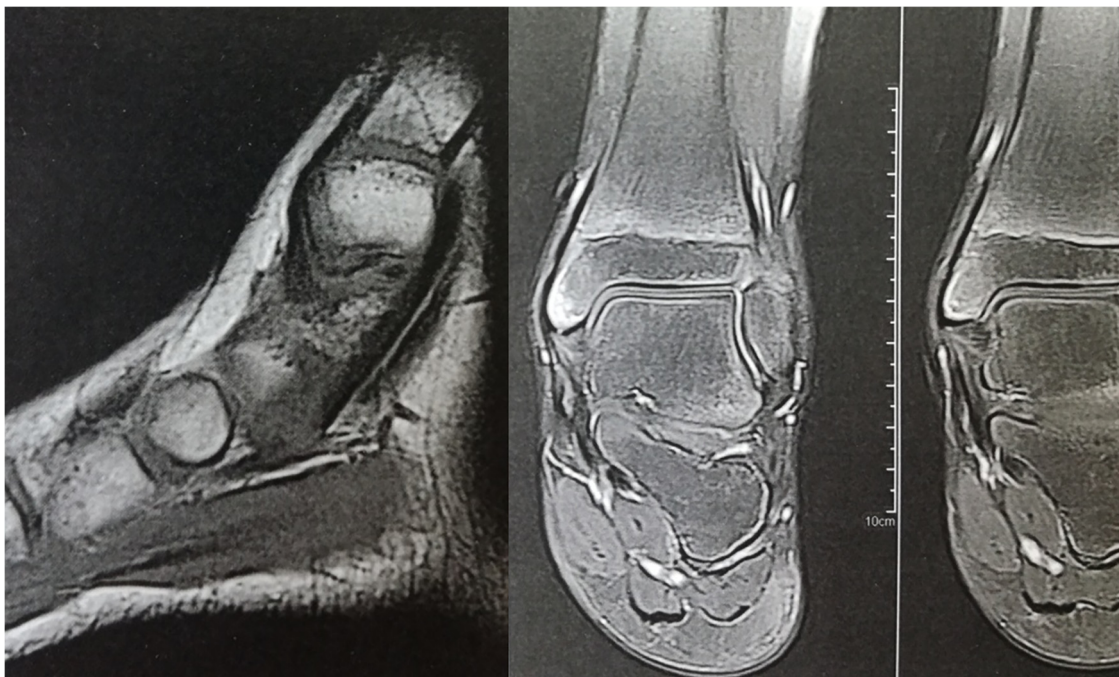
Sagittal T1-weighted and coronal T2-weighted magnetic resonance image show the area of osteochondritis of the left medial malleolus with low-signal intensity lesion on T1-images and a signal suggestive of sclerosis with bone marrow edema on T2-images. There is no alteration of articular cartilage of the ankle joint.
